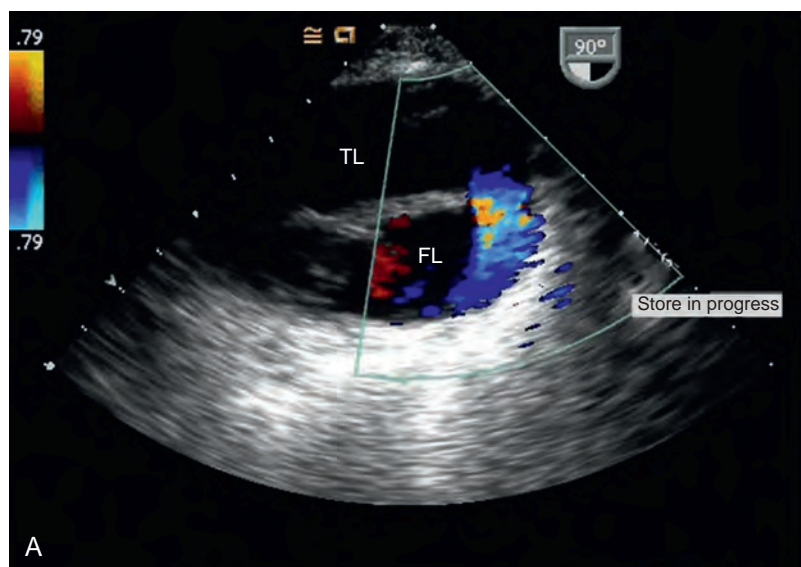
Intimal tear. (A) Primary dissection flap. Descending aortic long-axis view immediately distal to the left subclavian artery. A large dissection flap is visualized with nonrestricted blood flow from the true lumen (TL) to the false lumen (FL). (B) Secondary communications. Several smaller communications from the TL to the FL are seen from the true to FL, which probably represent the origin of intercostal arteries. (From Evangelista A, Flachskampf FA, Erbel R, et al. Echocardiography in aortic diseases: EAE recommendations for clinical practice. *Eur J Echocardiogr*. 2010;11:645–658.)
